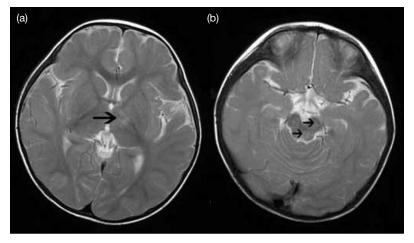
Axial T2-weighted magnetic resonance images showing hyperintensity (arrows) over (a) left thalamus and (b) brainstem, which demonstrate restricted diffusion on diffusion-weighted imaging (not shown) compatible with acute encephalitic changes
